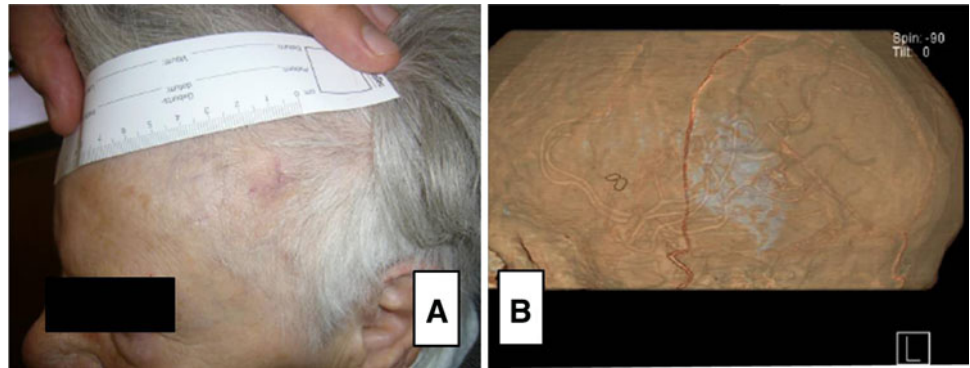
Two months postoperative findings. a Clinical evidence. No aesthetic defect. b Computed tomography angiography. No residual pseudoaneurysm, complete occlusion of frontal superficial temporal artery parietal branch patency
